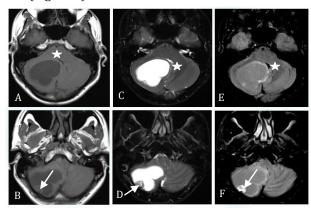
MRI Brain axial sections at the level of cerebellum showing a well-defined cystic lesion with few septations and an eccentric solid mural nodule in the right cerebellar hemisphere.
